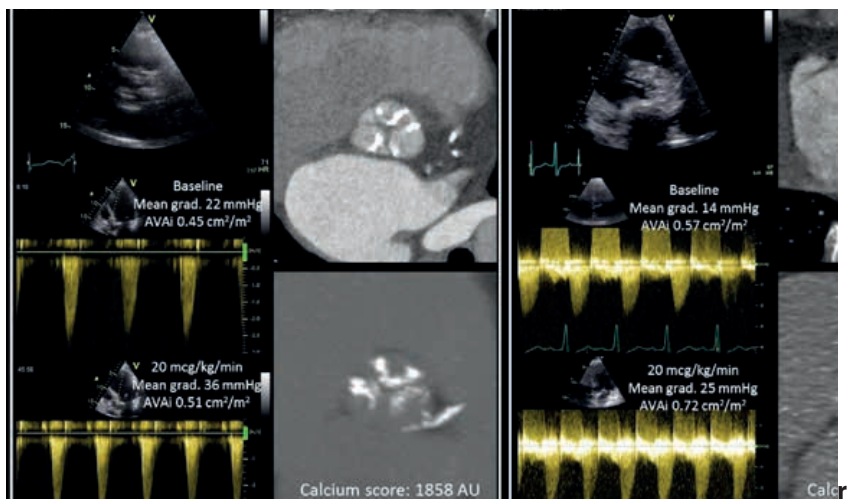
Aortic valve calcification burden assessed with computed tomography to differentiate between true and pseudosevere aortic stenosis. The left panel shows the example of an 85 year old patient with severe aortic stenosis and reduced left ventricular ejection fraction. During low dose dobutamine stress echocardiography, the mean gradient increased to 36 mmHg and the aortic valve area (AVA) remained $<0.6 \text{ cm}^2/\text{m}^2$. On computed tomography, the calcium score of the valve was 1858 AU (above the cut-off value proposed to define severe AS; see main text). The right panel shows the example of a 79 year old woman with severe aortic stenosis and reduced left ventricular ejection fraction. During low dose dobutamine stress echocardiography, the AVA increased $>0.6 \text{ cm}^2/\text{m}^2$ suggesting the diagnosis of pseudosevere AS. On computed tomography, the calcium score of the aortic valve was below the proposed cut-off value).
